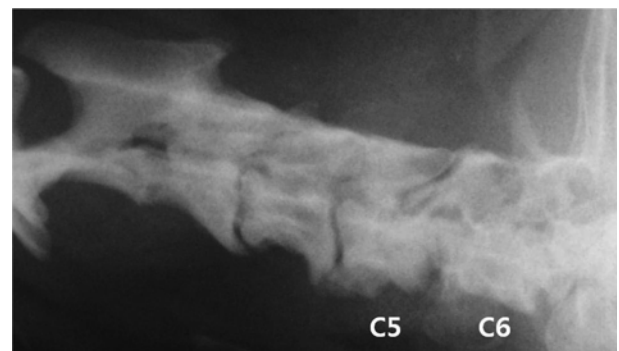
Four-month postoperative radiograph of a Pekingese treated using ventral slot decompression, cancellous bone graft and external coaptation. Osseous fusion and good alignment of C5-C6 are revealed.
